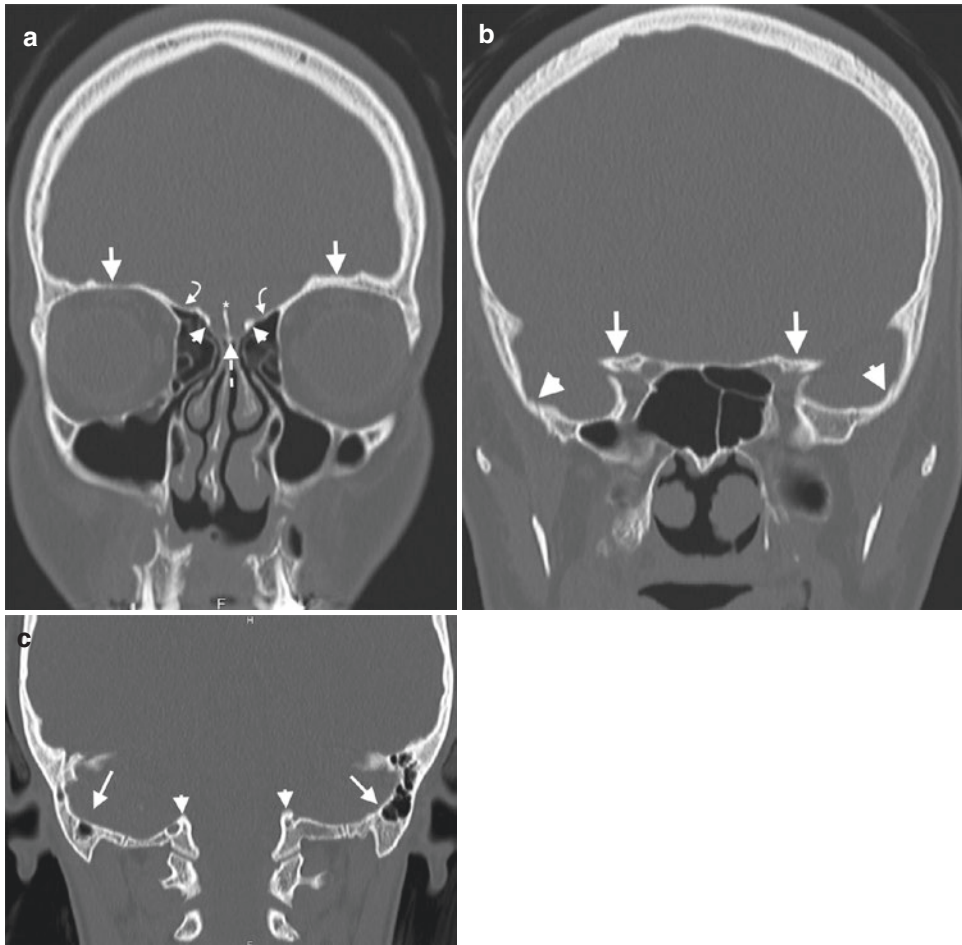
Coronal CT images revealing anatomic structures in ASB, MSB, and PSB. (a) ASB. Coronal CT image of ASB reveals bilateral orbital roofs (arrows), fovea ethmoidalis (curved arrows), lateral lamellae (arrowheads), CP (dashed arrow), and crista galli (*). (b) MSB. Coronal
